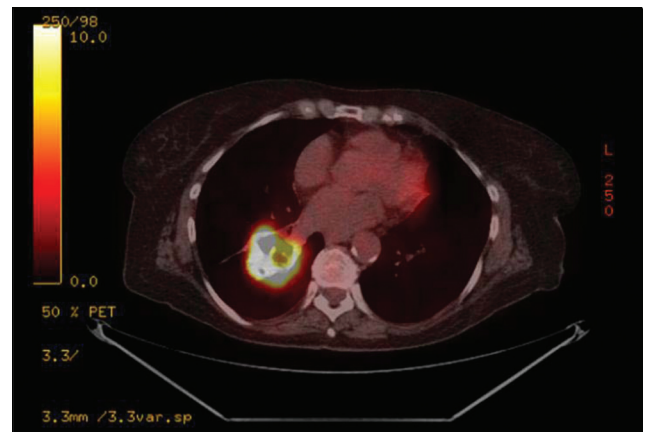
PET scan showing an R perihilar mass with cavitory features, measuring 3.8×4.8 cm, with an SUV of 22.5.
